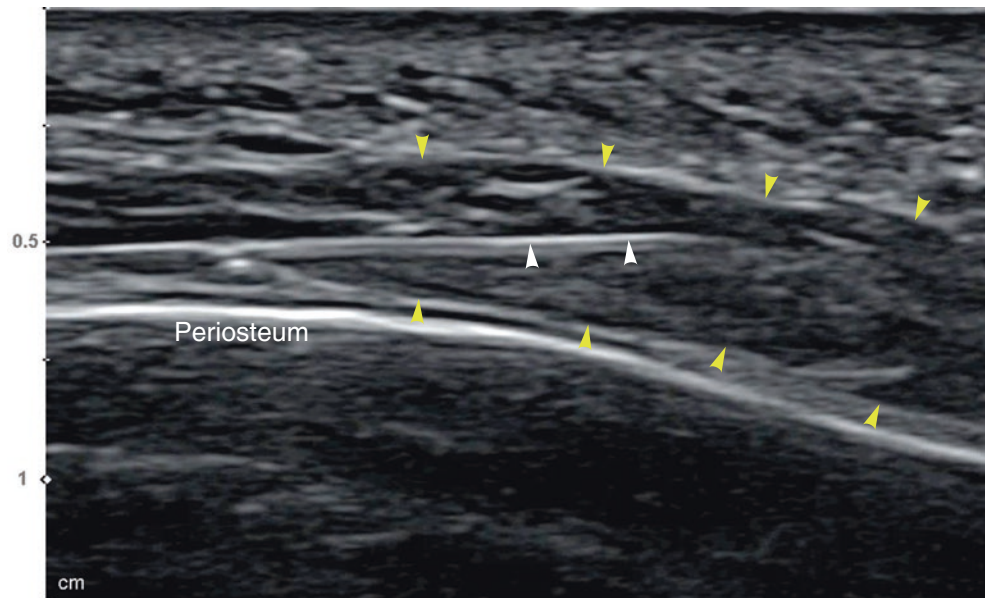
Ultrasonography of the foreign body granuloma on the forehead after the filler injection, B mode (transverse view, 15 MHz by linear transducer). (Published with kind permission of © Ji-Soo Kim 2020. All Rights Reserved)
